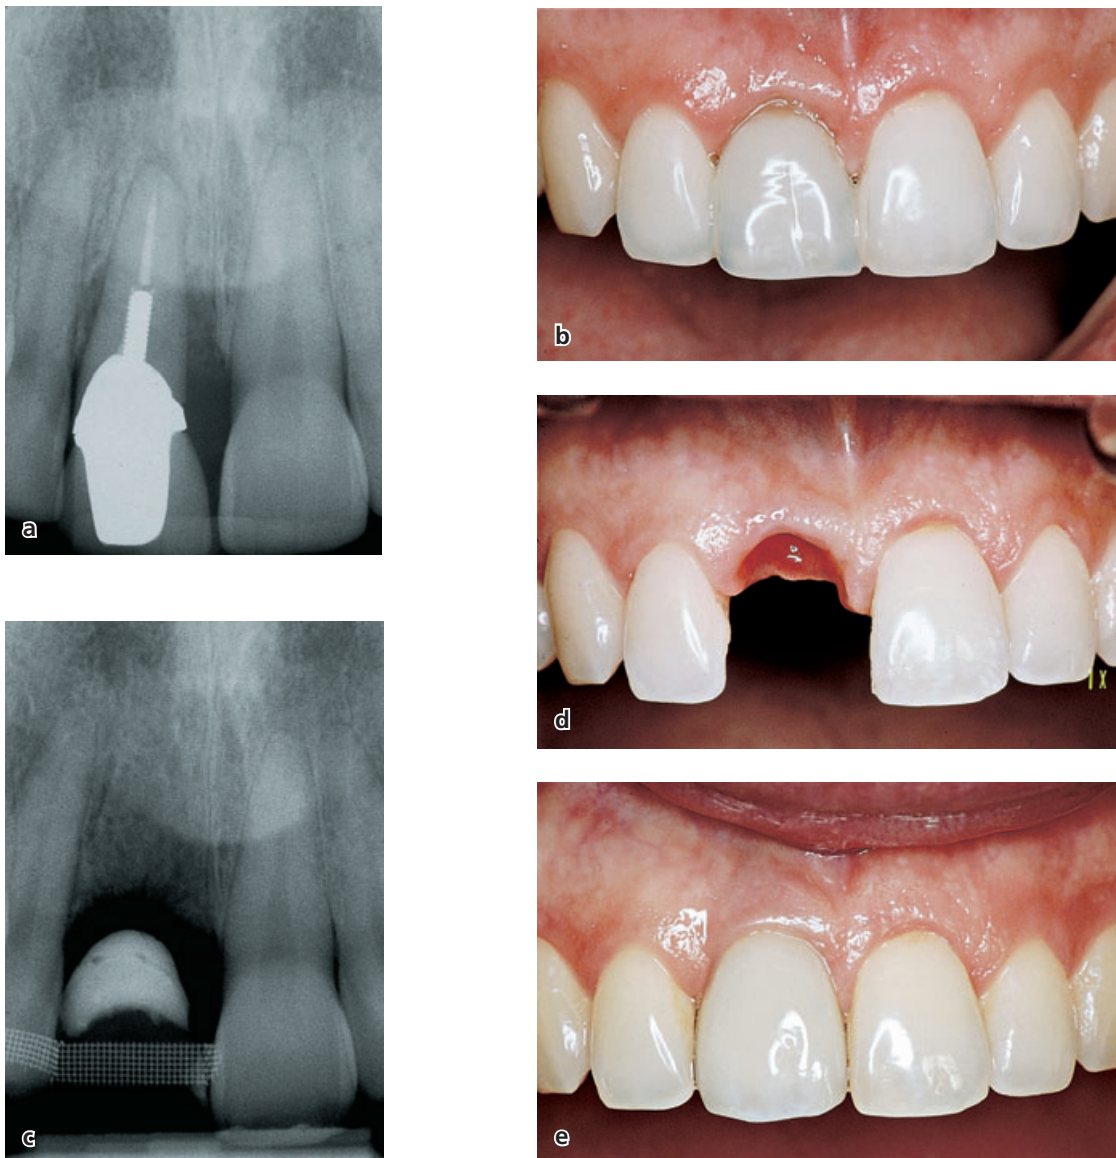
(a) A central incisor that cannot be maintained because of root fracture which also caused pronounced periodontal destruction. (b) Immediately following tooth extraction, an ovate pontic was inserted to support the facial and proximal soft tissues. (c,d) Radiographic and clinical view of the area 6 weeks after tooth extraction. (e) Follow-up 1 year after the placement of permanent prosthetic reconstruction (single implant).
